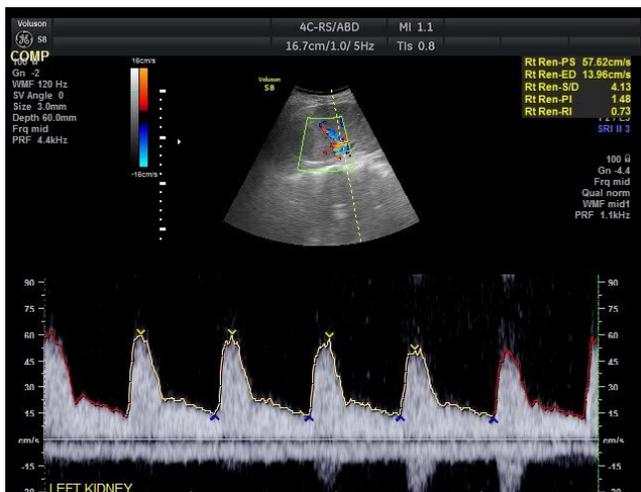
Renal Doppler ultrasonography demonstrates high-impedance flow in the left segmental artery of a 15-year-old male patient, as indicated by high PI and RI values (1.48 and 0.73, respectively)
